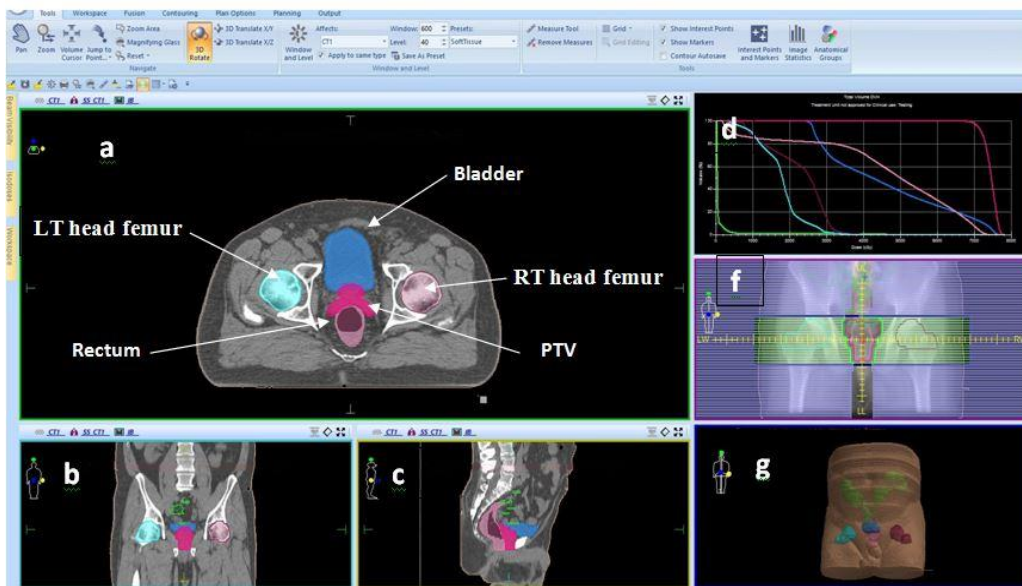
The patient contours of the planning target volume (PTV) and organs at risk (OARs) on computed tomography CT slices. (A) Patient contours on CT axial view, (b) patient contours on CT coronal view, (c) patient contours on CT sagittal view, (d) The dose-volume histograms (DVH), (f) the beam eye view BEV, (g) the patient 3D model
